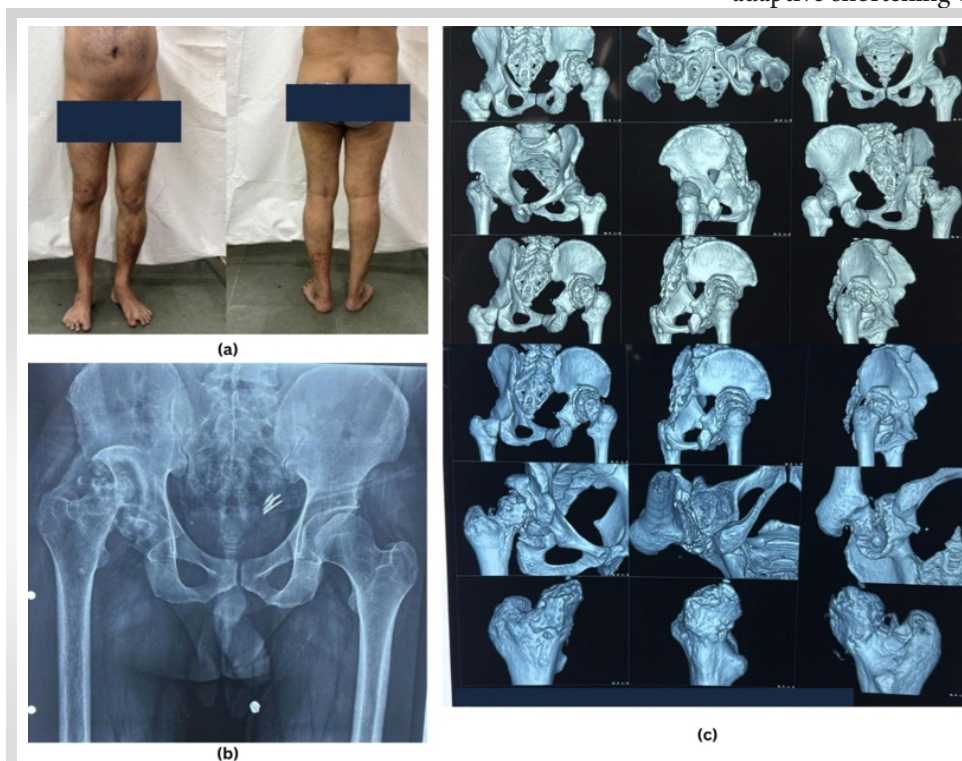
Pre-operative clinical and radiological assessment. (a) Clinical photographs showing limb length discrepancy and altered posture with appropriate groin coverage. (b) Pre-operative anteroposterior radiograph of the pelvis demonstrating neglected posterior dislocation of the right hip with superior migration of the proximal femur. (c) Three-dimensional computed tomography reconstruction demonstrating chronic posterior dislocation, distorted acetabular anatomy, and severe deformity of the proximal femur.
